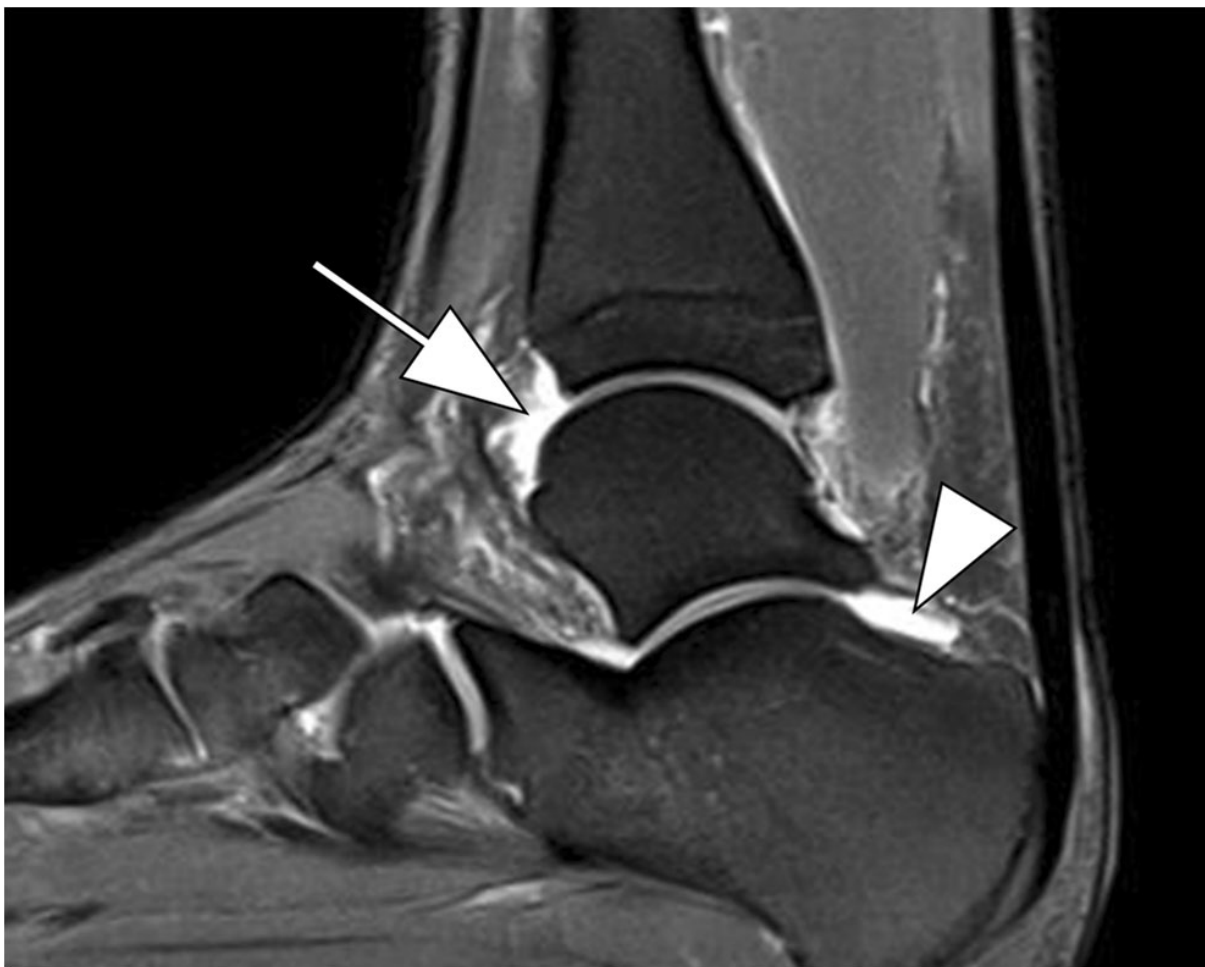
Sagittal fat-suppressed proton density-weighted MRI shows Grade 1 effusion in the tibiotalar (arrow) and the talocalcaneal (arrowhead) joints
